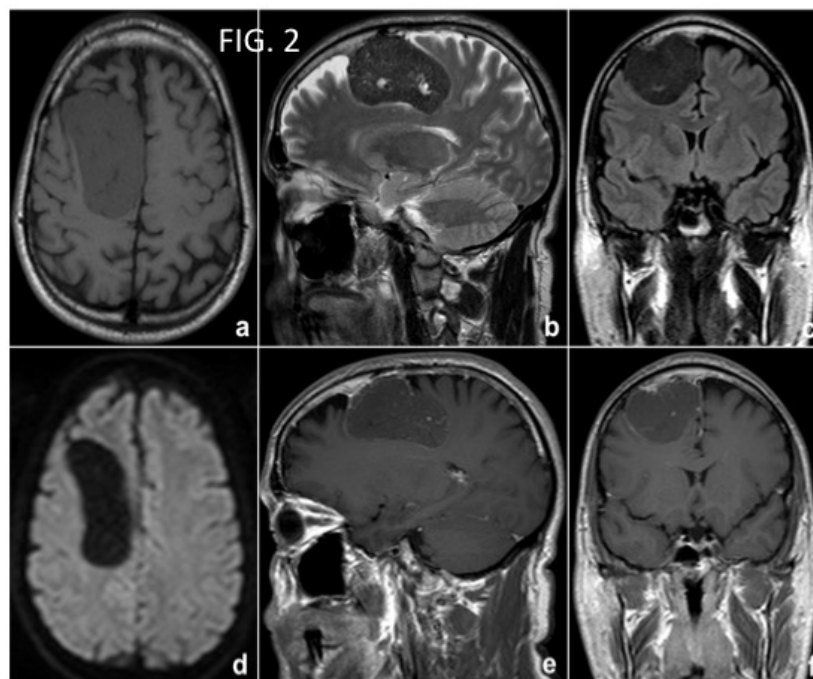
Transverse T1-weighted Spin-Echo (a) and sagittal T2-weighted Turbo Spin-Echo (b) MR images show a slightly inhomogeneous hypointense mass compared to cortex, arising from the inner surface of the cranial vault, with a thin rim of CSF between tumour and brain parenchyma (*cleft sign*) and no clear evidence of dural invasion. Coronal FLAIR MR image (c) shows moderate mass effect on adjacent structures, without brain tissue oedema. At Single Shot Diffusion Weighted Image (DWI) (d) no evidence of restricted diffusion was present. Sagittal and coronal T1-weighted Spin-Echo MR images after intravenous administration of Gadolinium (e-f) show poor contrast enhancement, limited to planting base and peripheral part of the lesion.
